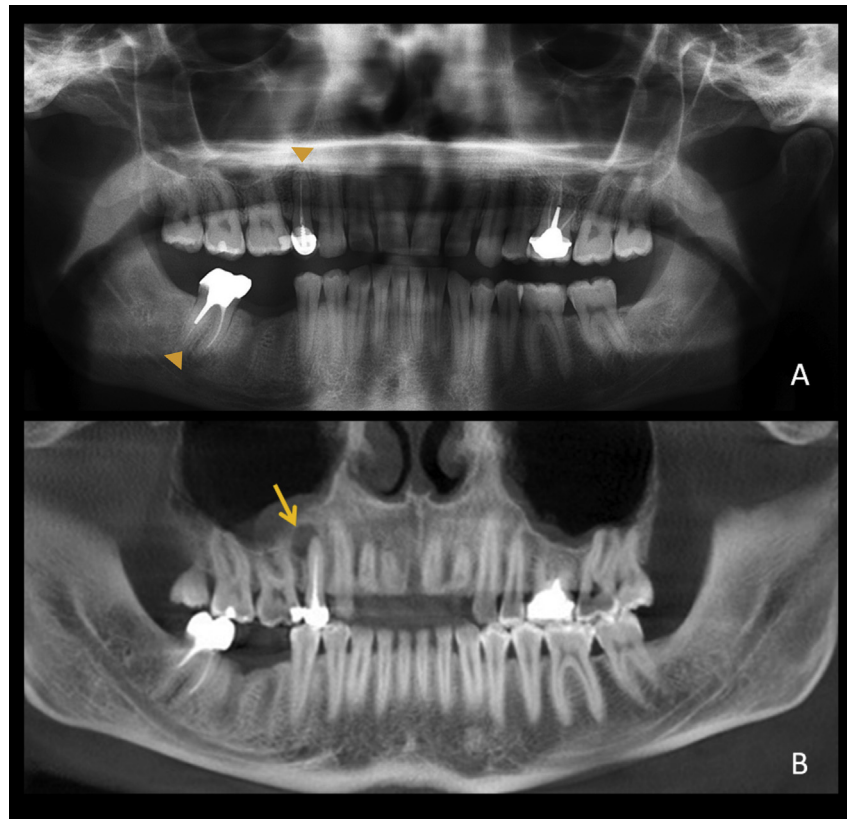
Comparison of conventional radiographs and cone-beam tomography (CBCT) in the detection of intraosseous bone changes. Conventional imaging represents a summation of all radiodensities in the path of the X-ray beam, while tomographic techniques represent local radiodensities and give an overall more accurate representation of osseous changes. A: Panoramic radiograph shows an apparently normal periapical area of the upper right premolar and the lower right second molar (arrowheads). Note that both teeth are root canal-treated (root canal filling evident as radiodense white lines). B: A reformatted CBCT image of the same patient shows an apical radiolucency (arrow) associated with the upper premolar but not the lower molar.
